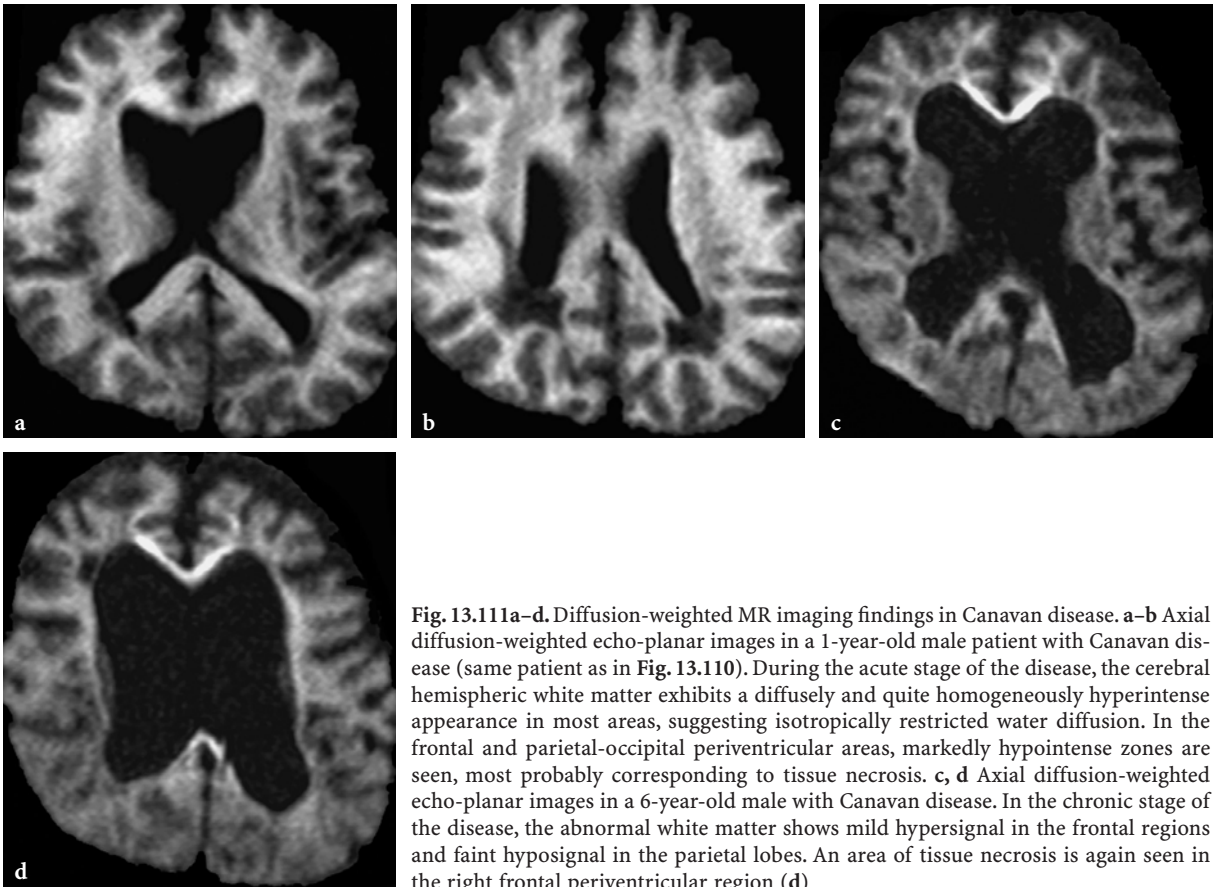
Diffusion-weighted MR imaging findings in Canavan disease. a–b Axial diffusion-weighted echo-planar images in a 1-year-old male patient with Canavan disease (same patient as in Fig. 13.110). During the acute stage of the disease, the cerebral hemispheric white matter exhibits a diffusely and quite homogeneously hyperintense appearance in most areas, suggesting isotropically restricted water diffusion. In the frontal and parietal-occipital periventricular areas, markedly hypointense zones are seen, most probably corresponding to tissue necrosis. c, d Axial diffusion-weighted echo-planar images in a 6-year-old male with Canavan disease. In the chronic stage of the disease, the abnormal white matter shows mild hypersignal in the frontal regions and faint hyposignal in the parietal lobes. An area of tissue necrosis is again seen in the right frontal periventricular region (d)
